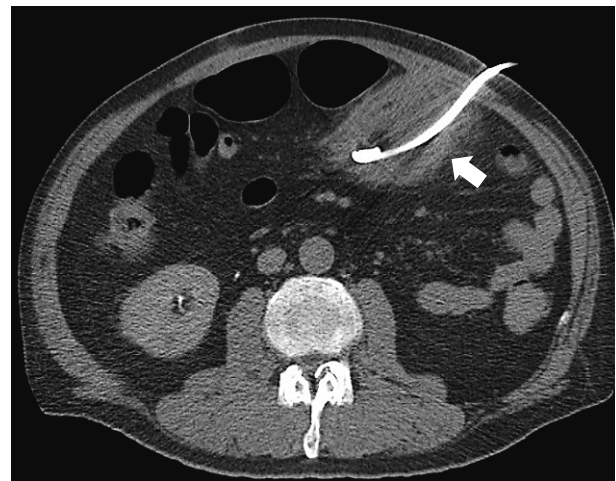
Axial plain CT image immediately after the procedure shows the drainage catheter (arrow) successfully placed in the target omental abscess.
